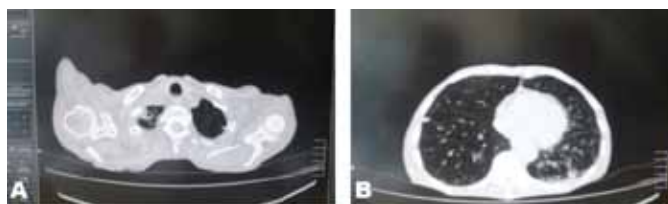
Computed tomography of chest showing (A) Thick and thin walled cystic bronchiectatic changes in apical segments of right upper lobe, (B) Small modular infiltrates are seen in left lower lobe and in lateral basal segment of right lower lobe.
